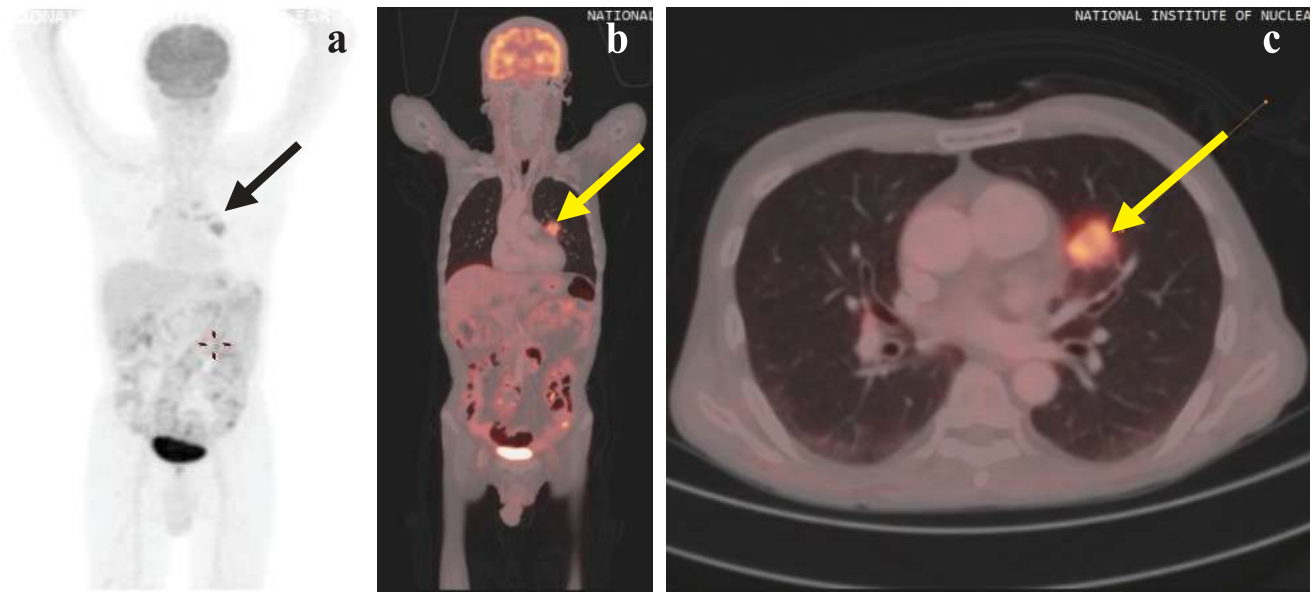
a. ¹⁸F-FDG PET MIP image showing hypermetabolic lesion in the mediastinum. The neck region appears normal, b. whole body coronal and c. transaxial fusion PET-CT images show hypermetabolic lesion in the upper lobe of left lung.
